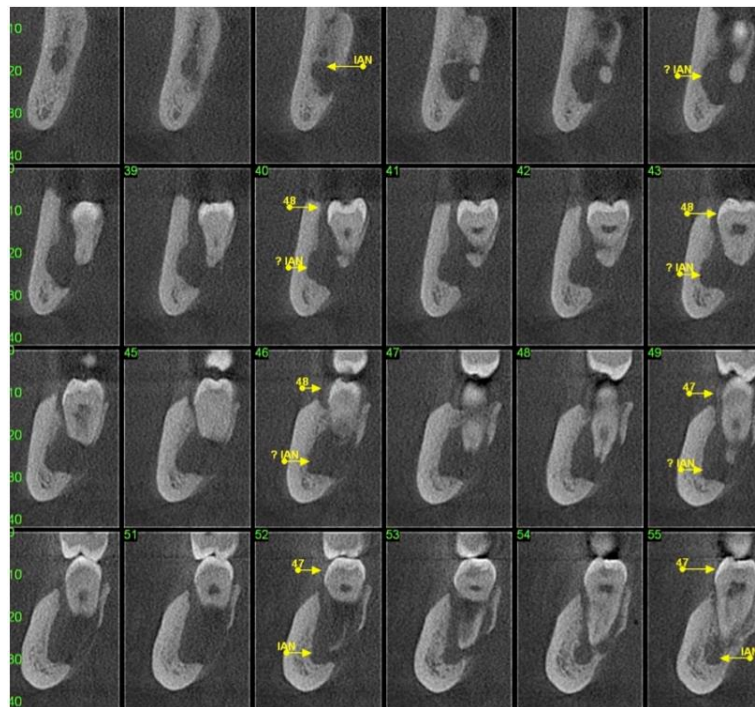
CBCT cuts showing radiolucent lesion associated with teeth 47 and 48 incorporating inferior alveolar nerve.
